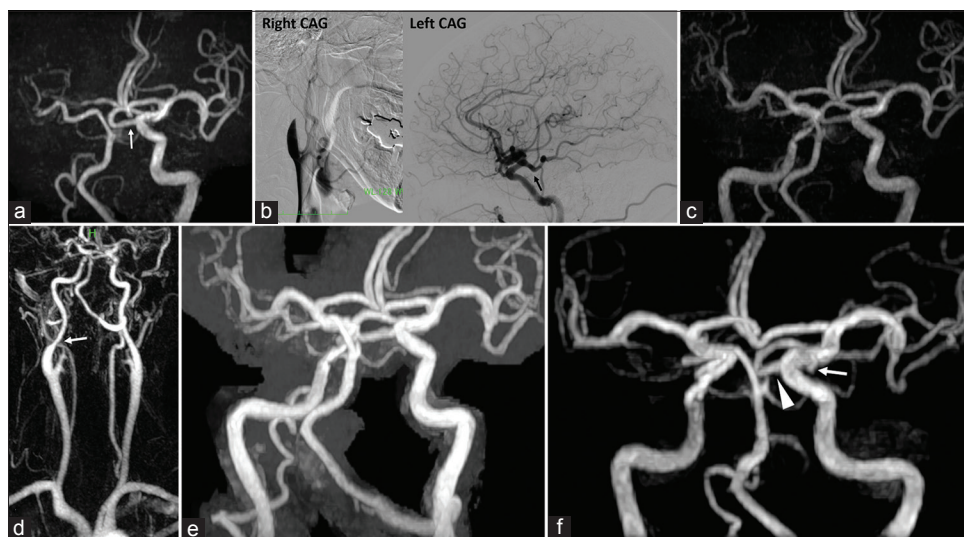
(a) Magnetic resonance angiography performed 7 years ago showing occlusion of the right internal carotid artery and a thick posterior communicating artery on the left (arrow). (b) Angiography showing occlusion of the right internal carotid artery and thick left posterior communicating artery (arrow). No aneurysmal protrusion can be seen in the left internal carotid artery. (c) Magnetic resonance imaging in the 5th month showing recanalization of the right internal carotid artery, and no aneurysm on the left internal carotid artery. (d) Magnetic resonance angiography after 8 months showing mild stenosis at the right internal carotid artery in the neck (arrow). (e) Magnetic resonance angiography after 9 months showing no cerebral aneurysm on the left internal carotid artery. (f) Magnetic resonance angiography obtained 38 months after cerebral infarction showing a small protrusion (arrow) on the left internal carotid artery at the bifurcation of the thick posterior communicating artery (arrowhead)
